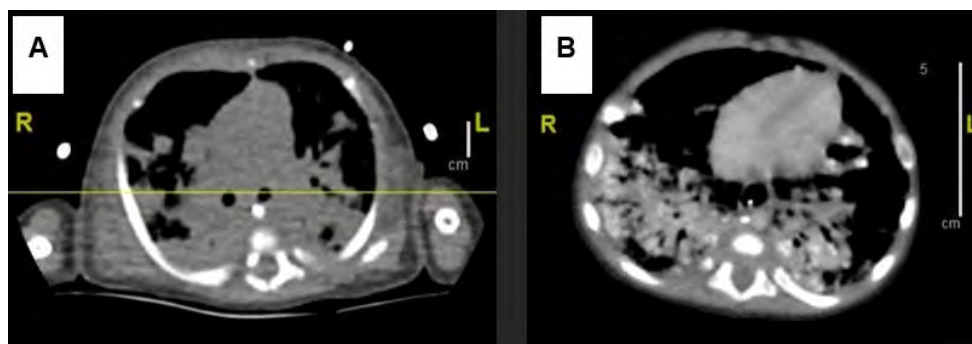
Chest CT at birth (A): Diffuse patchy nodular images of consolidation in both lung fields that coalesce to form larger areas of consolidation with air bronchogram. In LIL there is a zone in the area of greatest consolidation that could suggest the beginning of pulmonary cavitation; and 60 days later (B): Pulmonary granulomas, cavitations in the left lung and hilar and mediastinal adenopathies.
